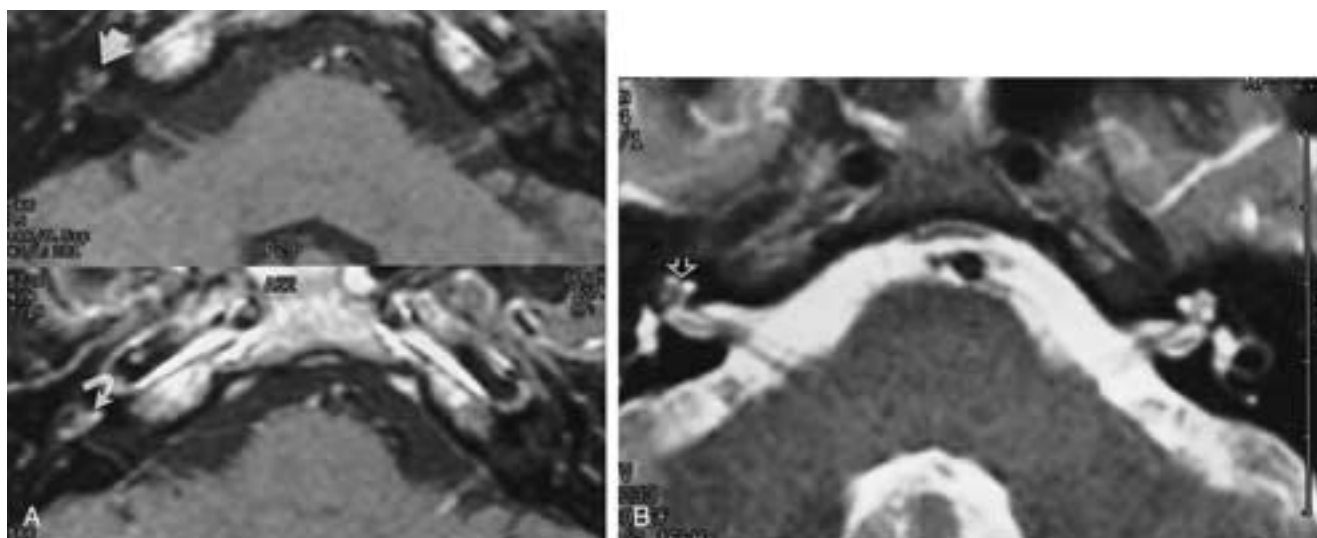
Labyrinthitis ossificans. A, T1-weighted axial images before (top) and after (bottom) gadolinium enhancement show mild hyperintensity of the cochlea on the unenhanced image (arrow), with intense enhancement after gadolinium enhancement (curved arrow). B, T2-weighted axial MR image demonstrates replacement of the normal bright signal of the membranous labyrinth (open arrow).
